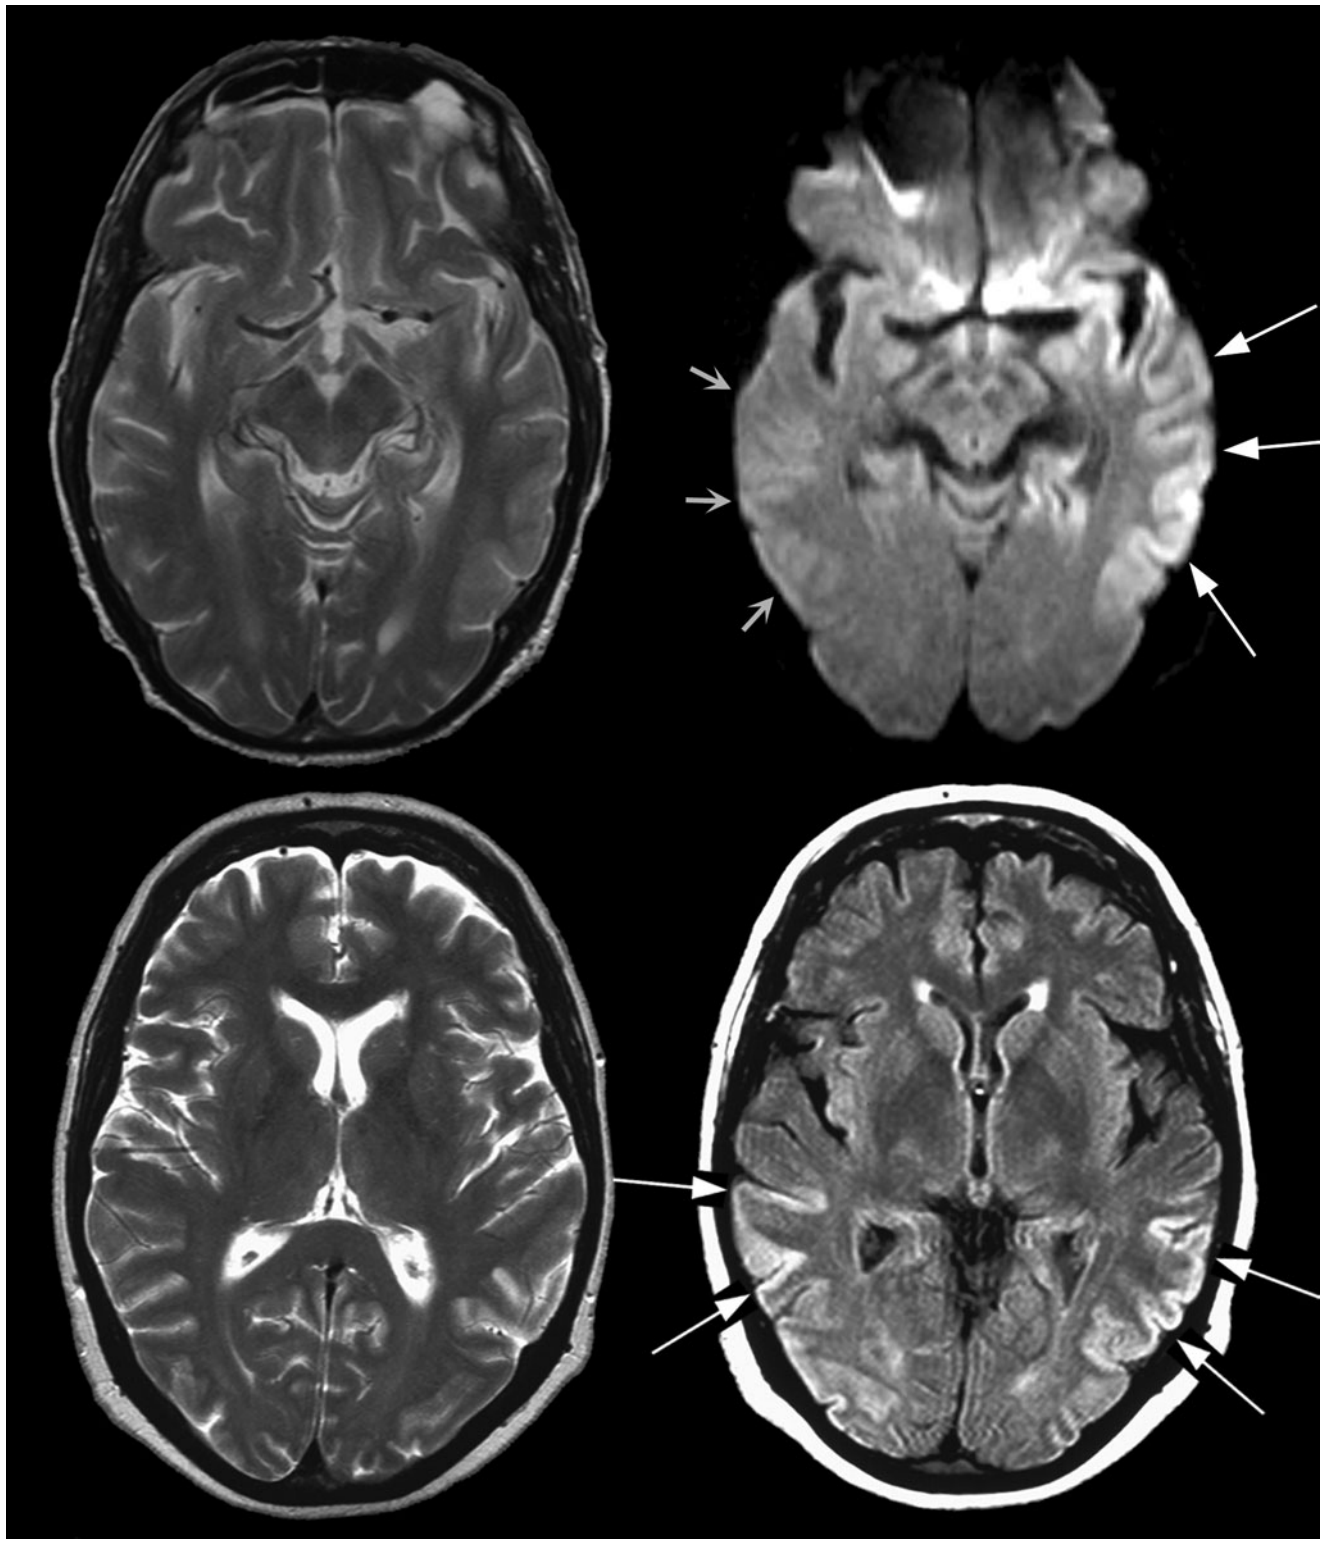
Magnetic resonance imaging in patients with Creutzfeldt-Jakob disease.
